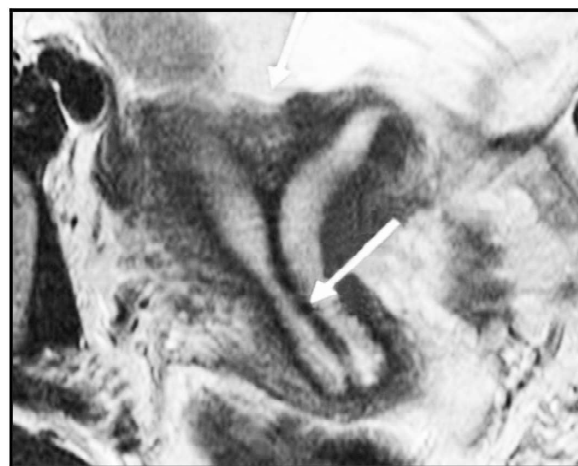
MRI of complete septate uterus
